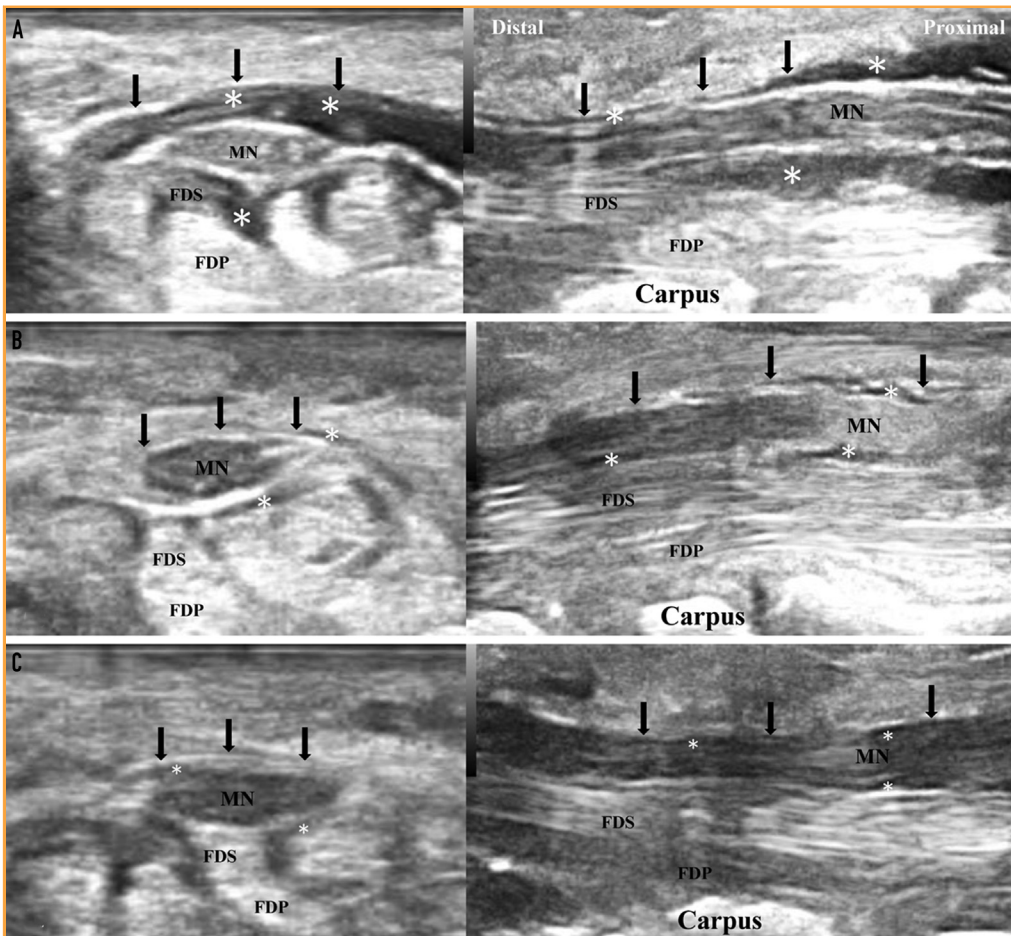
Follow-up ultrasonography imaging after injection (left: transverse view; right: long axial view). (A) Immediately after injection: The injectate (*) can be observed between the flexor retinaculum (arrows), median nerve, and flexor tendons. (B) Thirty minutes after injection: Most injectate (*) is absorbed. (C) One hour after injection: The injectate (*) is completely absorbed. FDP = flexor digitorum profundus; FDS = flexor digitorum superficialis; MN = median nerve.
